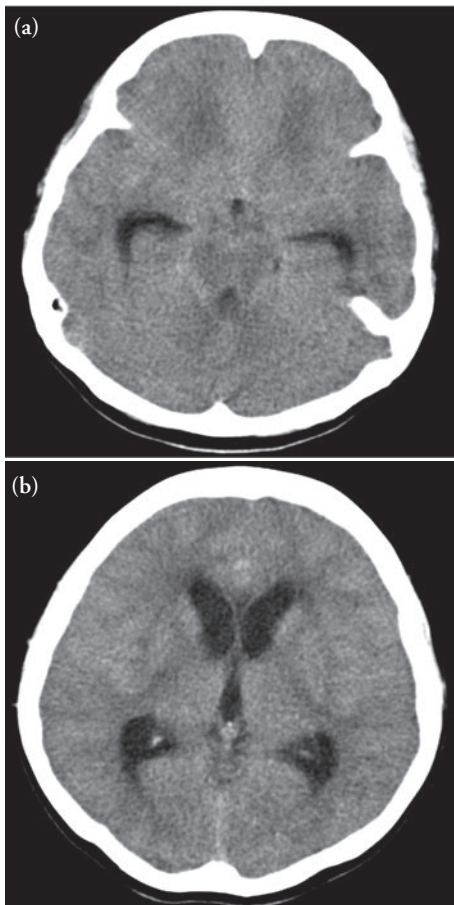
Non-contrast axial CT scan of brain at different levels.
